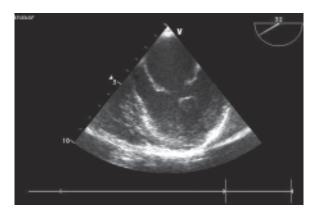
Transoesophageal echocardiography revealed Libman- Sacks Endocarditis with mitral regurgitation.
